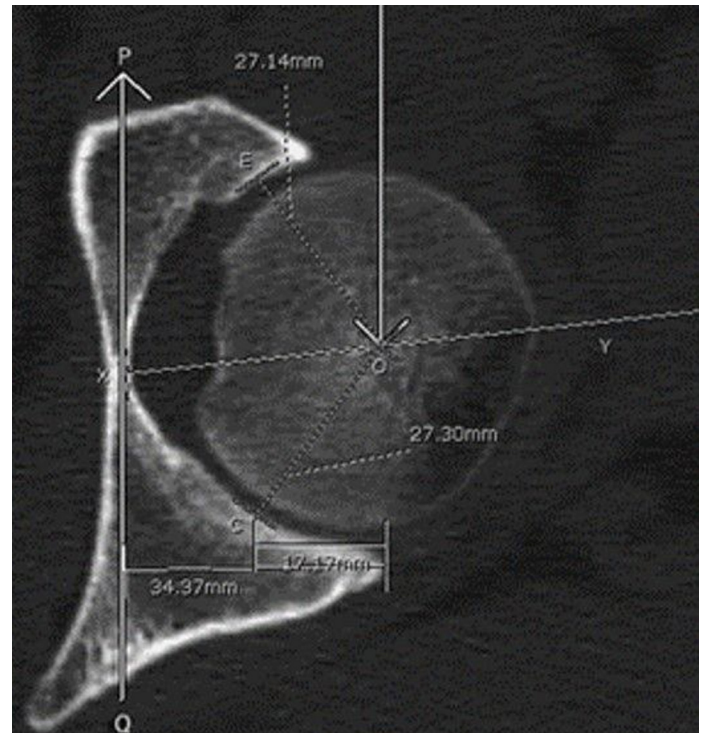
The photograph of computed tomography imaging intact posterior wall (8).
